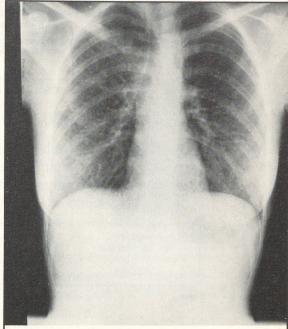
Chest x-ray taken eight days after admission to the hospital.
